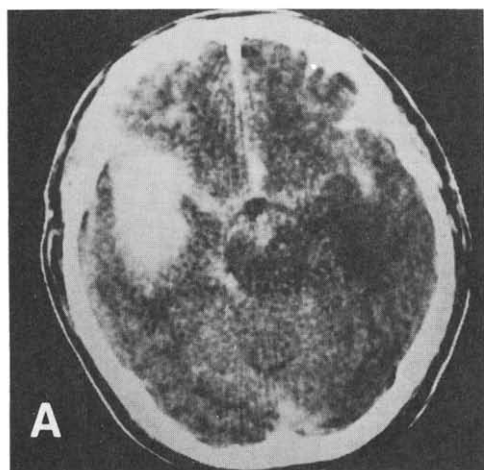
Case 1. (A) Preoperative CT scan showing a hematoma in the right temporal lobe and SAH in the basal cisterns. (B) CT scan 1 day after surgery showing disappearance of the hematoma. (C) CT scan 7 days after surgery disclosing the right subgaleal and epidural hematomas with a marked midline shift from right to left.
